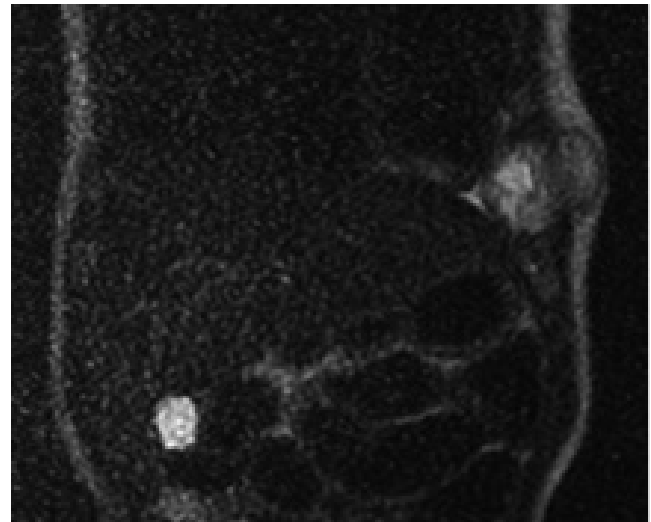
Mass lesion with a central hyperintense appearance, cystic-necrotic structure, hypointense solid structure on the periphery, and extending into the soft tissue in coronal T2W MRI examination
